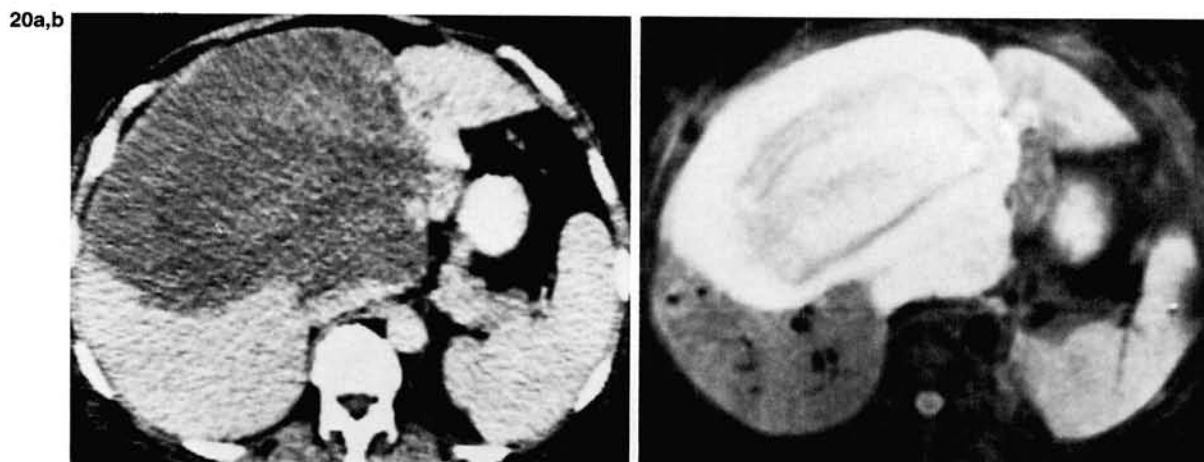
Hemangioma with left lobe atrophy: contrast enhanced CT (a) and inversion recovery (IR)_{1,500/100/44} (b) scans. The atrophic left lobe is highlighted in (b).
